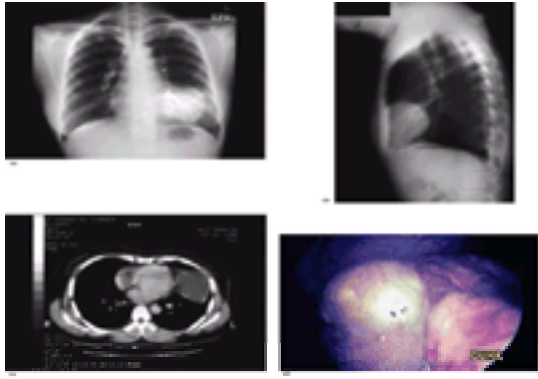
A middle-aged female with a mass on the left side of the chest on radiography (a,b). CT scan shows a cystic mass next to the pericardium (c). Thoracoscopic view of the pericardial cyst (d).
